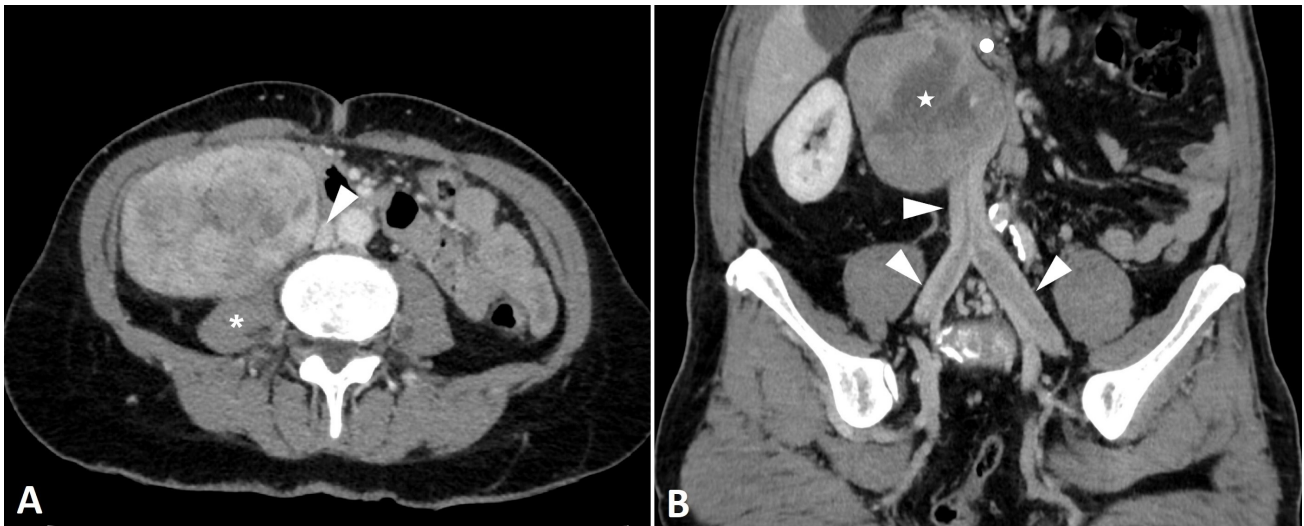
Retroperitoneal extravascular leiomyosarcoma. (A) Abdominal-pelvic computed tomography (CT) scan with intravenous contrast medium on axial plane (venous phase) in another patient affected by retroperitoneal extravascular leiomyosarcoma: a voluminous inhomogeneously vascularized mass occupies almost entirely the right iliac fossa, dislodging medially the inferior vena cava (arrowhead) and slightly compressing the right psoas muscle (asterisk), but without signs of infiltration. (B) Abdominal-pelvic CT scan with intravenous contrast medium on para-coronal plane (venous phase) in a patient affected by a retroperitoneal leiomyosarcoma with combined extravascular and intravascular growth: a large, mostly necrotic, mass (star) occupies the great vessel compartment of the retroperitoneum, dislocating the pancreatic head (dot), while the intravascular component of the neoplasm consist in a inhomogeneously vascularized filling defect in the lumen of the inferior vena cava and of both iliac veins (arrowheads).
